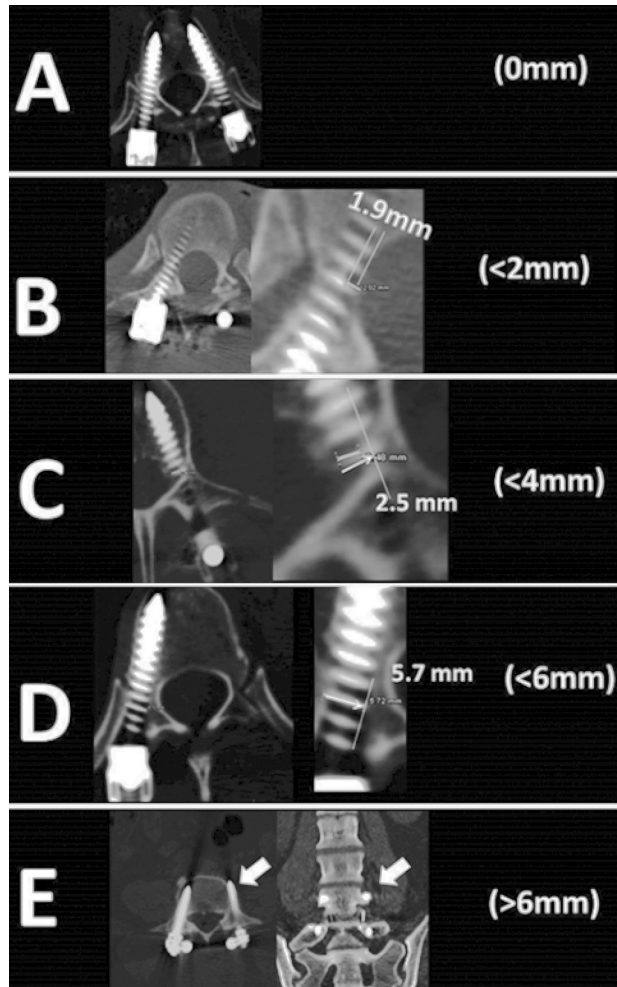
Computed tomography scans demonstrating the Gertzbein and Robbins classification. The grading system reflects the deviation of the screw from the “ideal” intrapedicular trajectory. The grades are as follows: A is an intrapedicular screw without breach of the cortical layer of the pedicle. B describes a screw that breaches the cortical layer of the pedicle but does not exceed it laterally by more than 2 mm. C and D reflect a penetration of less than 4 and 6 mm, respectively. We attributed Grade E to screws that do not pass through the pedicle or that, at any given point in their intended intrapedicular course, breach the cortical layer of the pedicle in any direction by more than 6 mm. Note that the screw that was marked with “D” has a deviation of more than 4 mm from the intrapedicular directory. However, in this case of a thoracic pedicle screw this deviation was intentional. Because of the very thin pedicles, we used the in-out-in technique to allow for optimal screw purchase in this case. [Derived from reference number 4 with permission].
